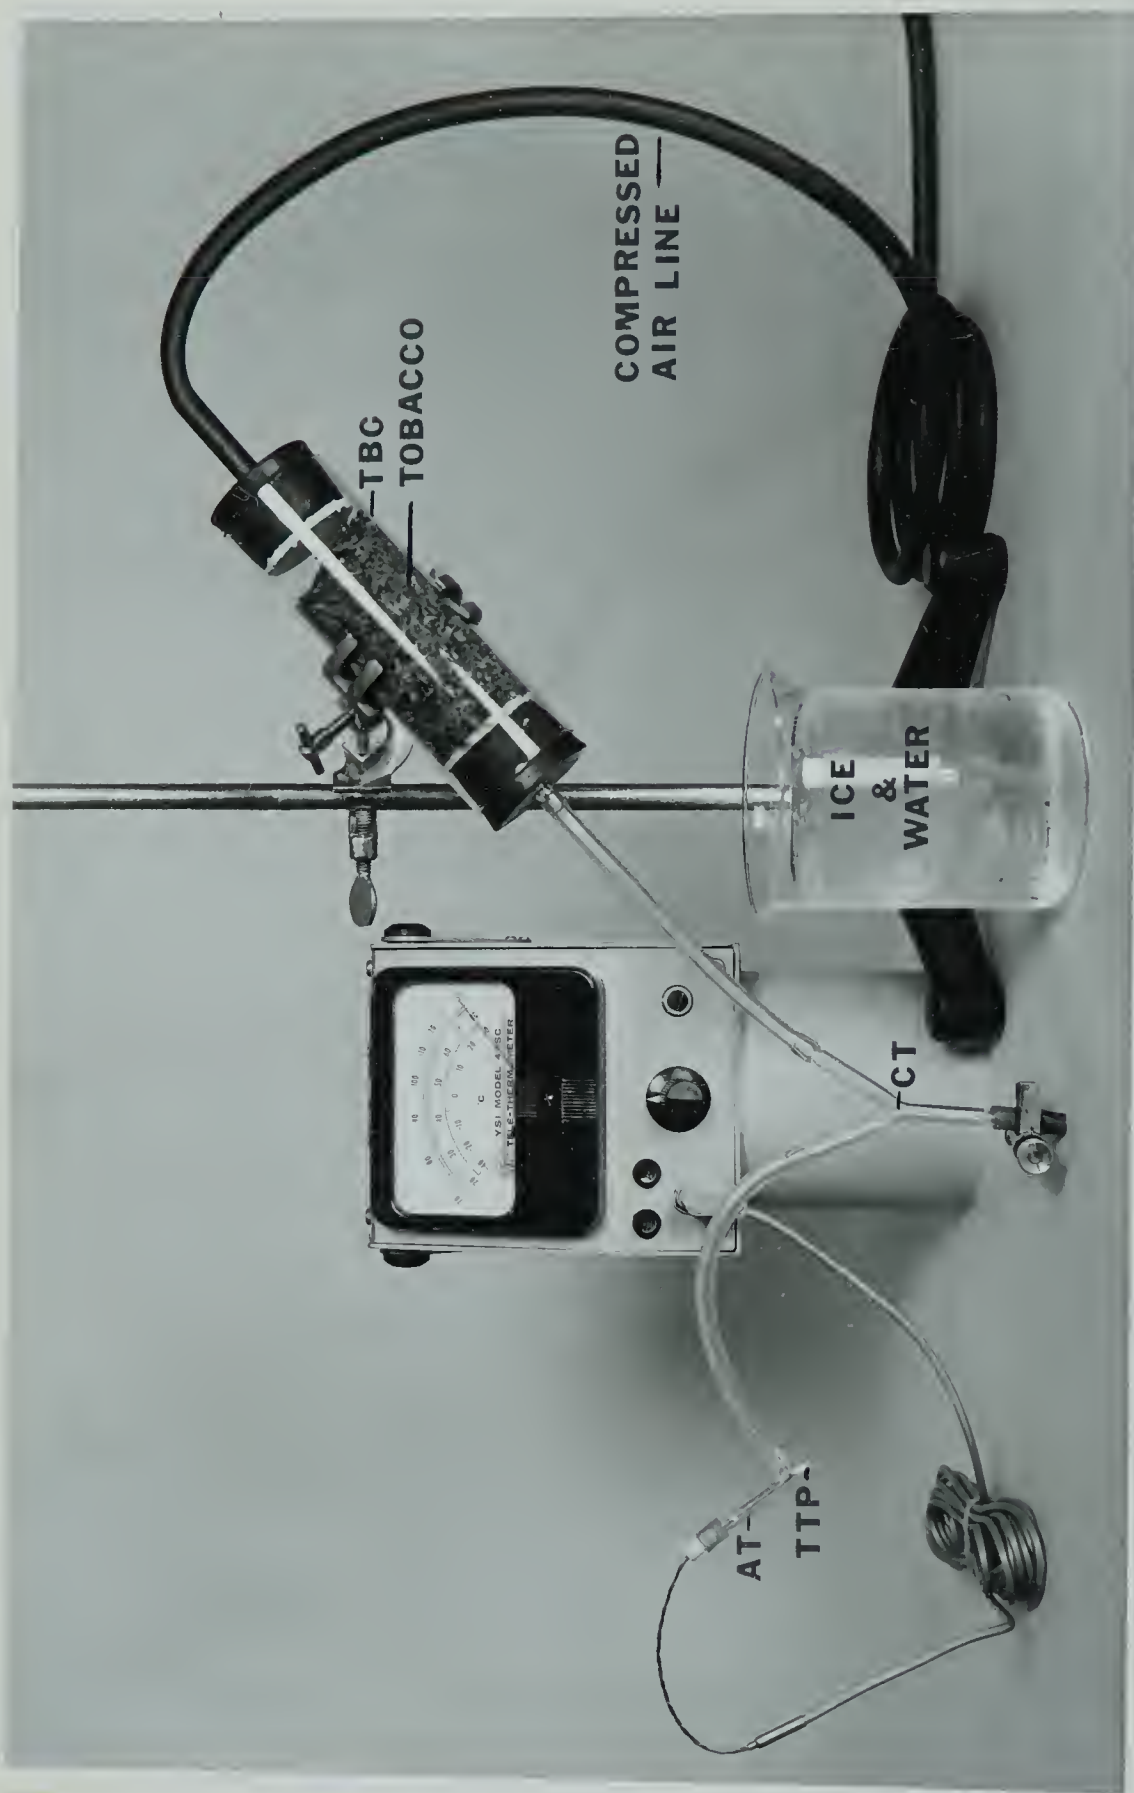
Smoke Application Apparatus. Tobacco burning chamber (TBC) with tobacco; compressed air line; condensate trap (CT) with pinch valve; applicator tip (AT) containing tele-thermometer probe (TTP); tele-thermometer and ice water.
